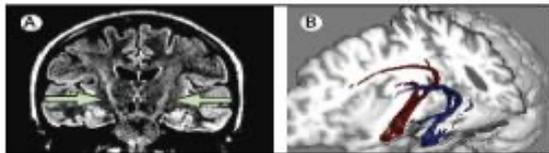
Standard and experimental MRI sequences in patients with ALS. (A) T2-weighted FLAIR sequence shows hyperintense corticospinal tracts in a patient with ALS on this coronal view (arrows), but this feature is neither sensitive nor specific in the absence of other more obvious clinical symptoms. (B) Diffusion tensor tractography is a research-based MRI technique that has potential to study extramotor and motor neuronal pathway involvement in ALS (superior oblique cut-out brain section viewed from left). In this patient with an unusual ALS phenotype that included prominent aphasia, reconstruction of the temporal lobe white matter projection fibres indicated that there were fewer fibres on the left (blue) compared with the right (red) side. ALS=amyotrophic lateral sclerosis. FLAIR=fluid-attenuated inversion-recovery.
